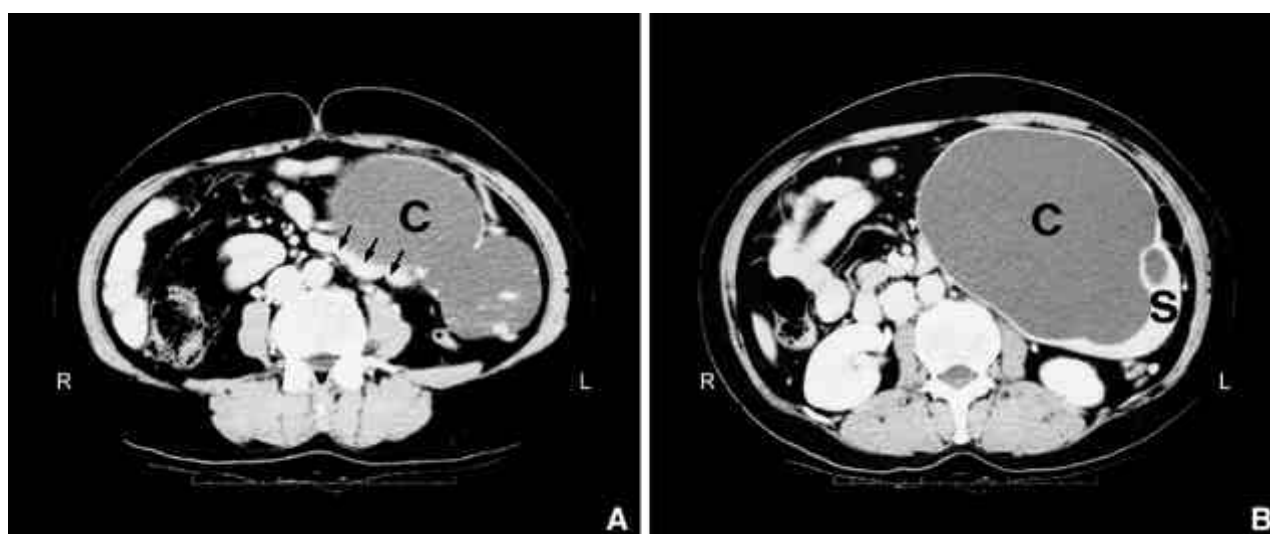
Abdominal computed tomography. A huge cystic mass is connected to the pancreatic tail, compressing the pancreas (arrows) (A). Solid component, which was later revealed to be an accessory spleen, shows the same homogenous attenuation as the spleen (B). C, cystic component of the mass; S, solid component of the mass.
